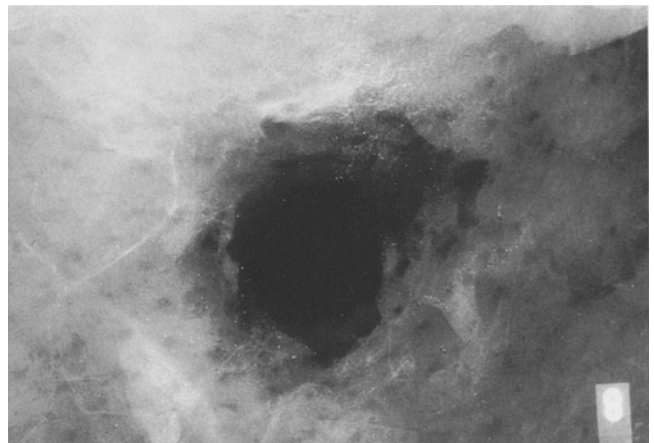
Smoke residues surrounding of an entry wound by direct X-ray magnification (3 ×)
